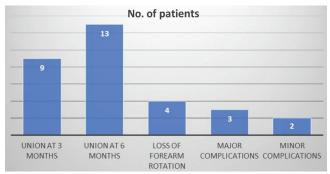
Frequency of patients with radiographic outcome, functional outcome and complications with intramedullary nailing
